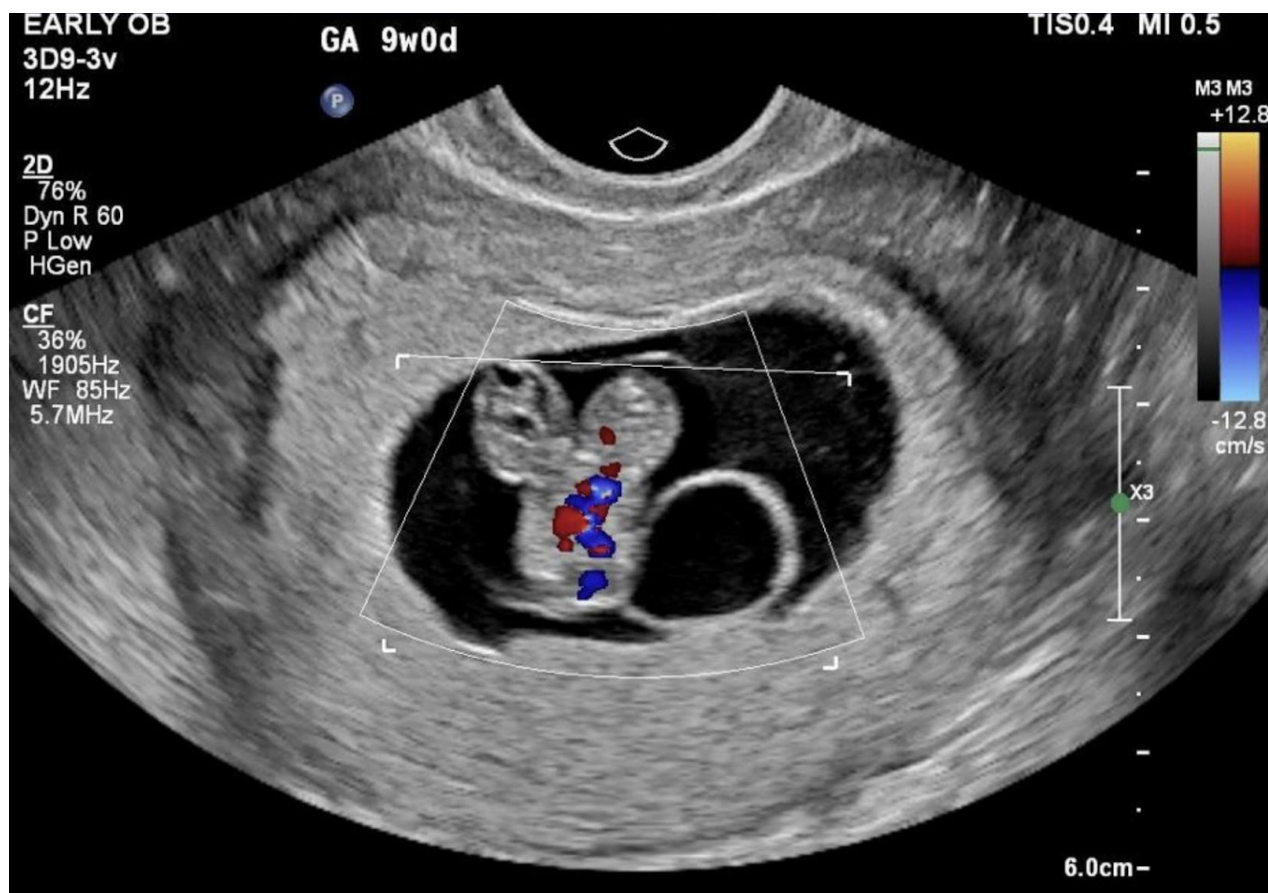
Diagnosis of conjoined twin pregnancy via ultrasound at 9 weeks and 0 days. Two heads and a single cardiac structure
